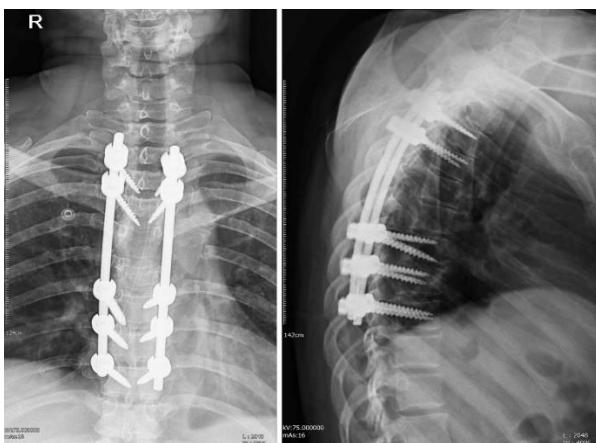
Post-operative X-ray [anteroposterior (AP) and lateral views]
